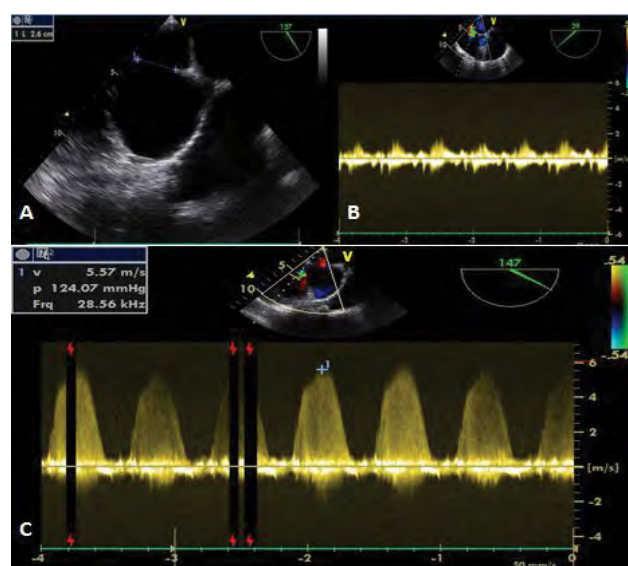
Transesophageal echocardiography revealed ostium secundum atrial septal defect measuring 26 mm (A) with bidirectional shunt (B) and severe pulmonary artery hypertension (systolic pulmonary arterial pressure at 135 mmHg) (C).
